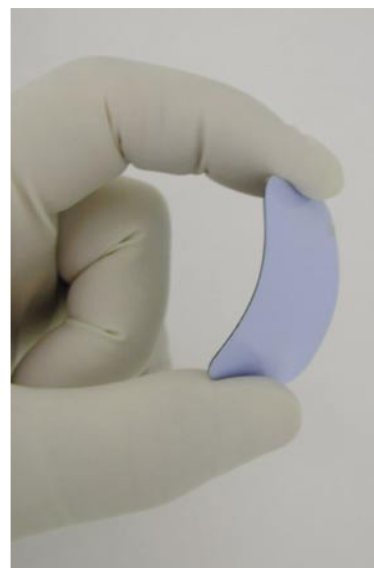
The appearance and consistence of the active phosphorous sensor are similar to those of a traditional radiographic film.
